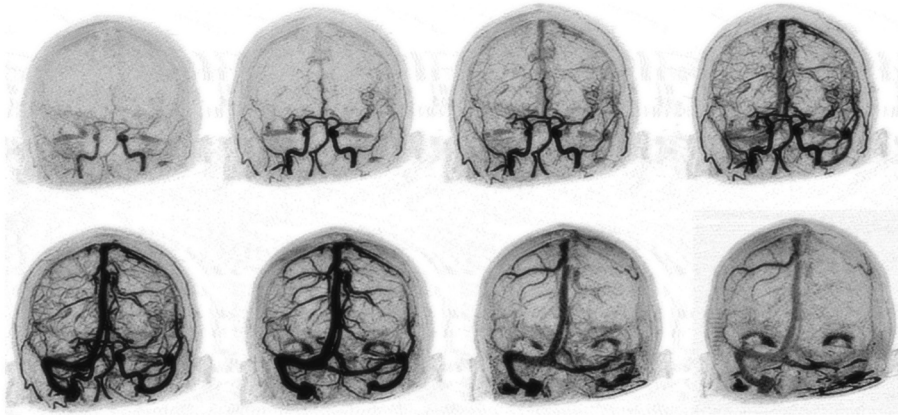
An example of dynamic CT angiography. Maximum intensity projection (MIP) images in coronal plane of 8 (of total 19) time points are shown. The cerebral vessels can be viewed to fill in with contrast dynamically over time. The upper left image depicts the first time point (early arterial phase), whereas the lower right image depicts the last time point (late venous phase). In the example above, a middle cerebral artery (M1 segment) occlusion at the right side is shown with delayed venous outflow of the right hemisphere.
